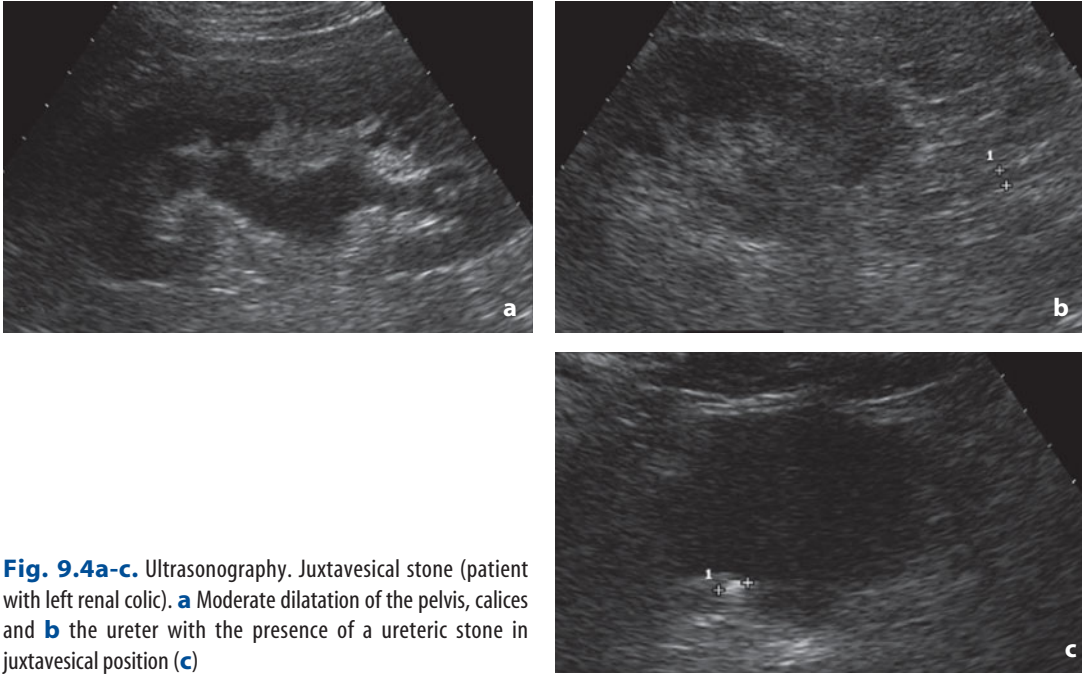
Ultrasonography. Juxtavesical stone (patient with left renal colic). a Moderate dilatation of the pelvis, calices and b the ureter with the presence of a ureteric stone in juxtavesical position (c)
